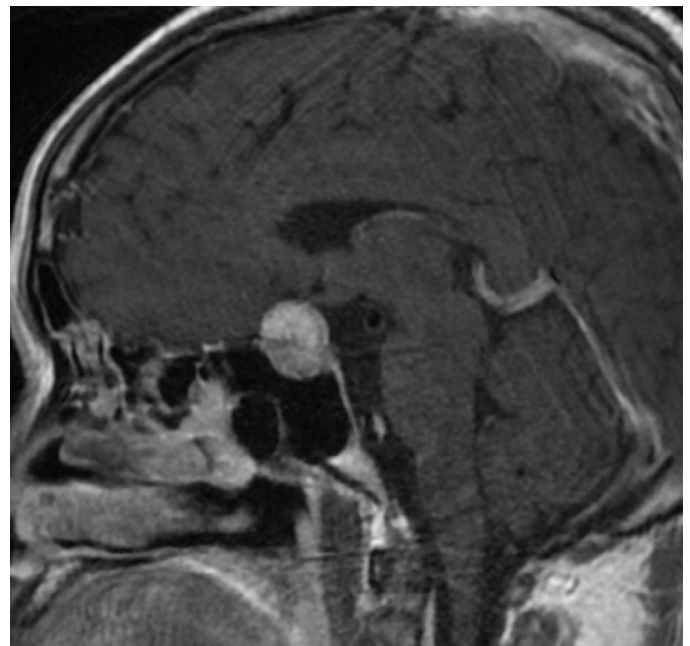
MRI of brain showing large pituitary mass.
